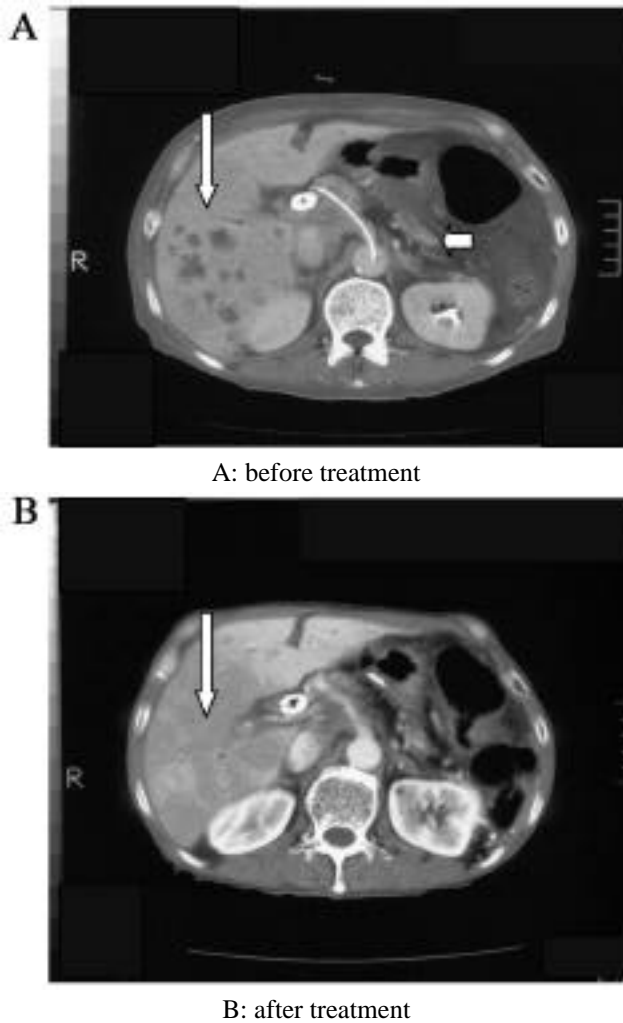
The CT images of Patient No. 8 before and after the treatment with TXT+5'-DFUR. the solid vertical arrow indicates a stent in common bile duct, and the horizontal arrow indicates an obstructed infusion catheter.
